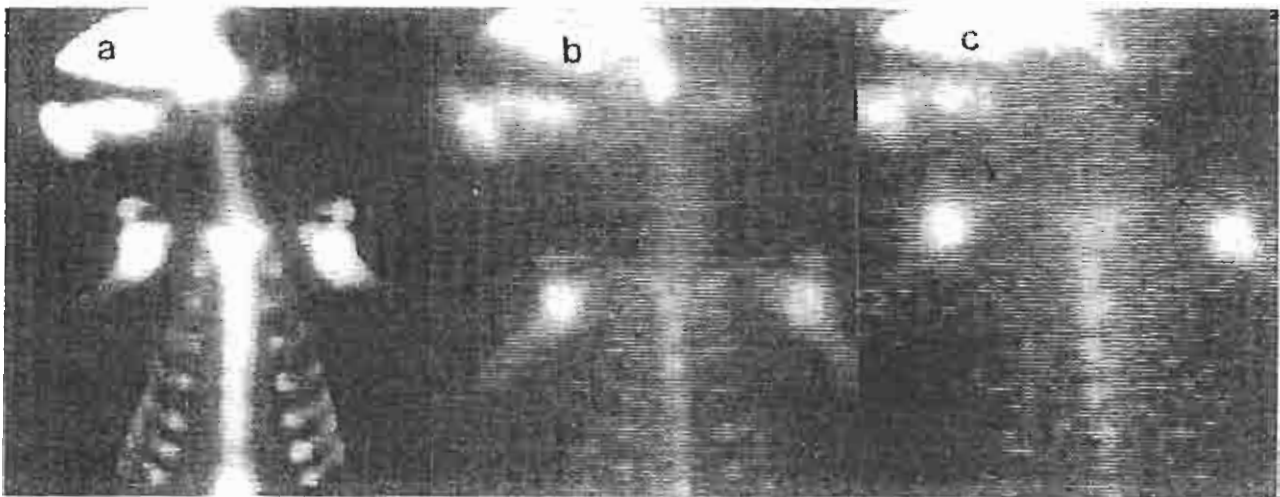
Typical scintigrams of baboons indicating skeletal localisation of (a) ^{99m}Tc -MDP (185 MBq), (b) ^{153}Sm -EDTMP (111 MBq), and (c) ^{166}Ho -EDTMP (185 MBq) 4 h postinjection.
